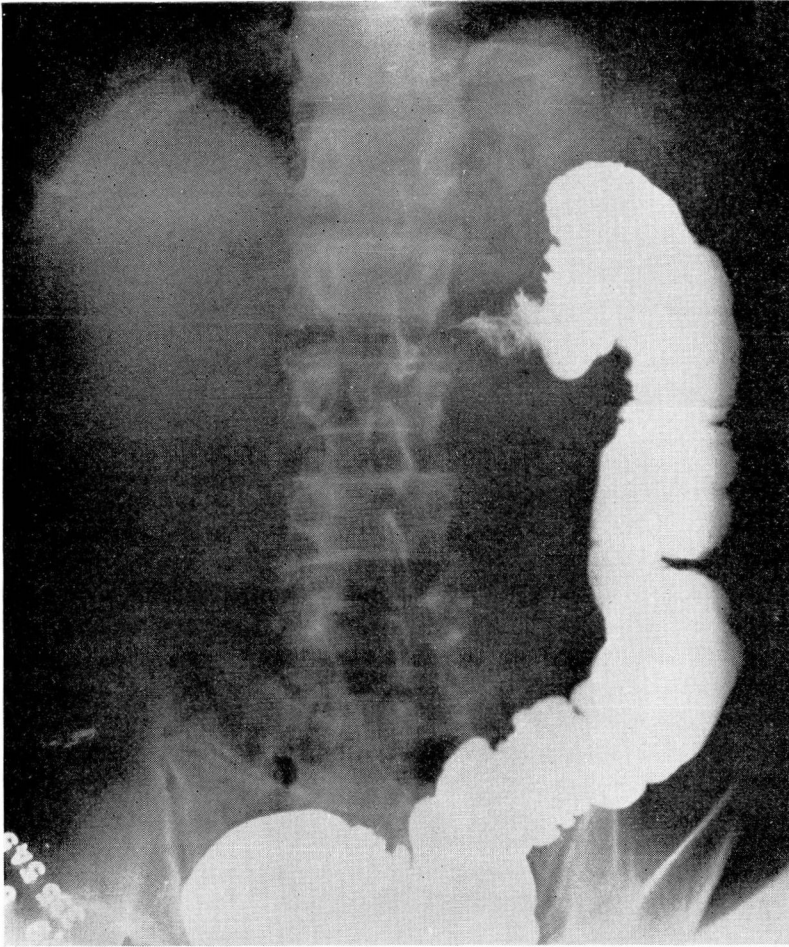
Roentgenogram of the abdomen 48 hours after barium meal, showing an annular, obstructing lesion just proximal to the splenic flexure of the colon.
